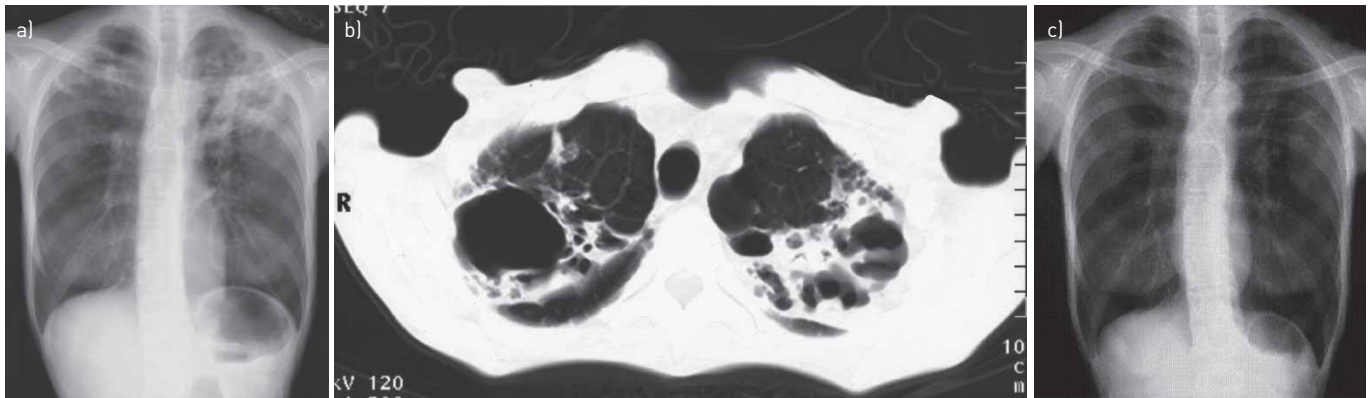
Chest imaging showing the patient's pulmonary lesions. a) Chest radiograph before initiating treatment showing bilateral cavities in the upper lobes of the lungs; b) chest computed tomography scan showing bilateral cavitory lesions surrounded by infiltrations in the apices of the lungs; c) chest radiograph 3 months after completing treatment showing a reduction in the size of the apical cavities.
